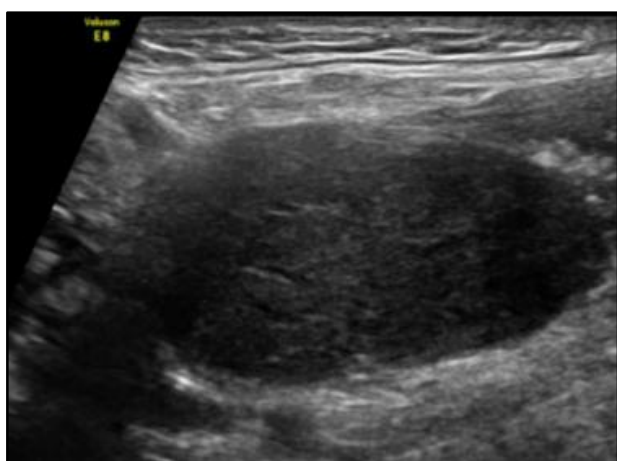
(a) Transverse sonogram of right level IV cervical lymph node in a 53-year-old man, B-mode sonography on the left showed B-mode score of 8, Elastography on the right showed pattern 3 (score 6).
